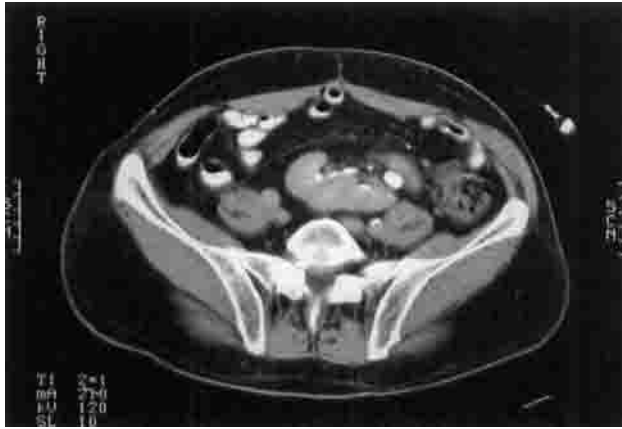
CT demonstration of right pelvic kidney situated against the right common iliac vessels.
